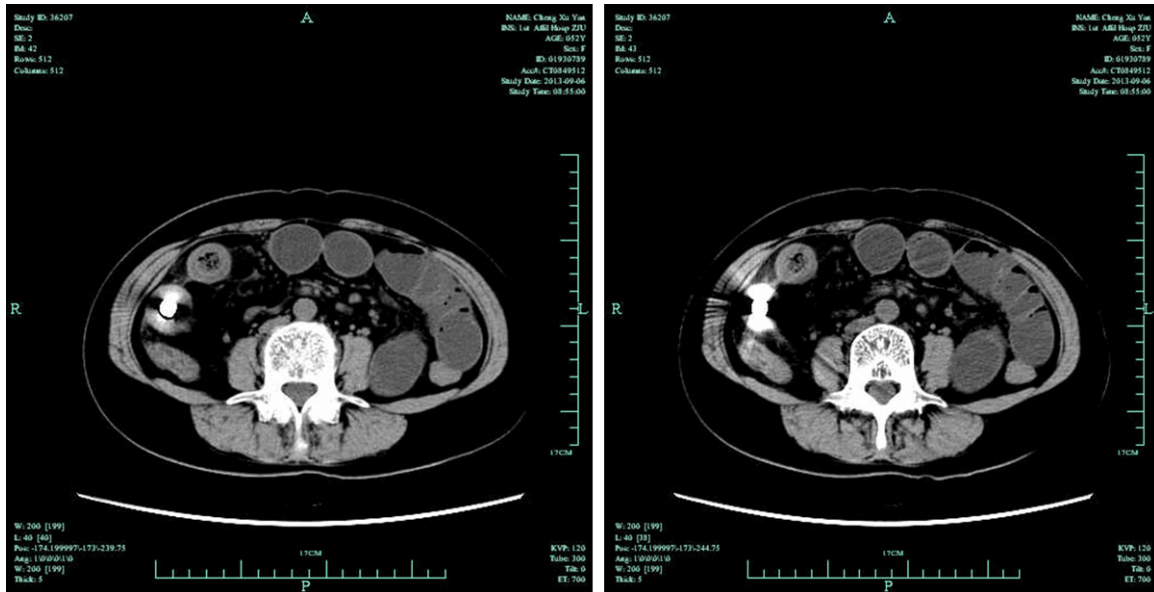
CE retention in CT.
